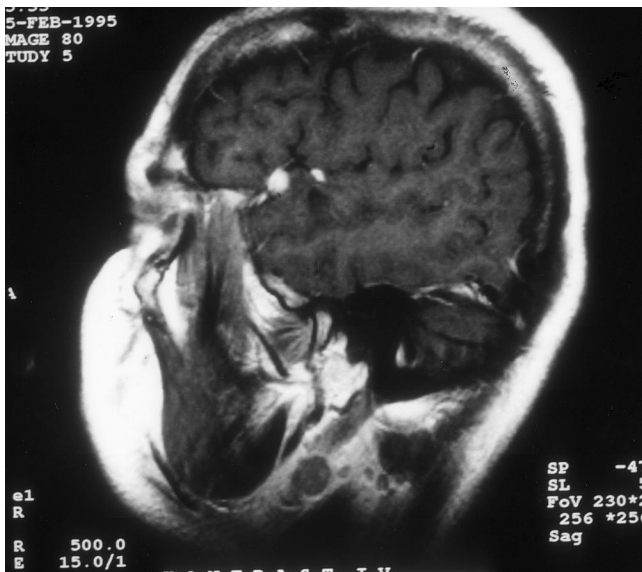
Gadolinium-enhanced T1-weighted sagittal magnetic resonance image showing two small, distinct tumors in the right superior temporal gyrus close to the sylvian fissure. There are no signs of leptomeningeal involvement
